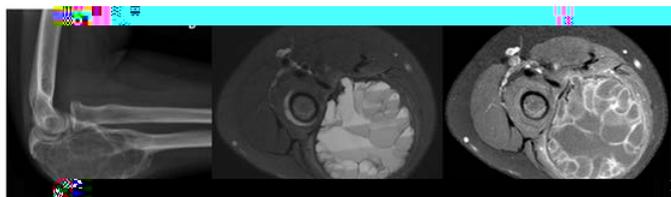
ABC, female, 12 years old, proximal ulna, type IB (radiography and MRI), filled with fluid-fluid level, no solid component, no aggressive imaging characteristic, no fracture. Score 2.
